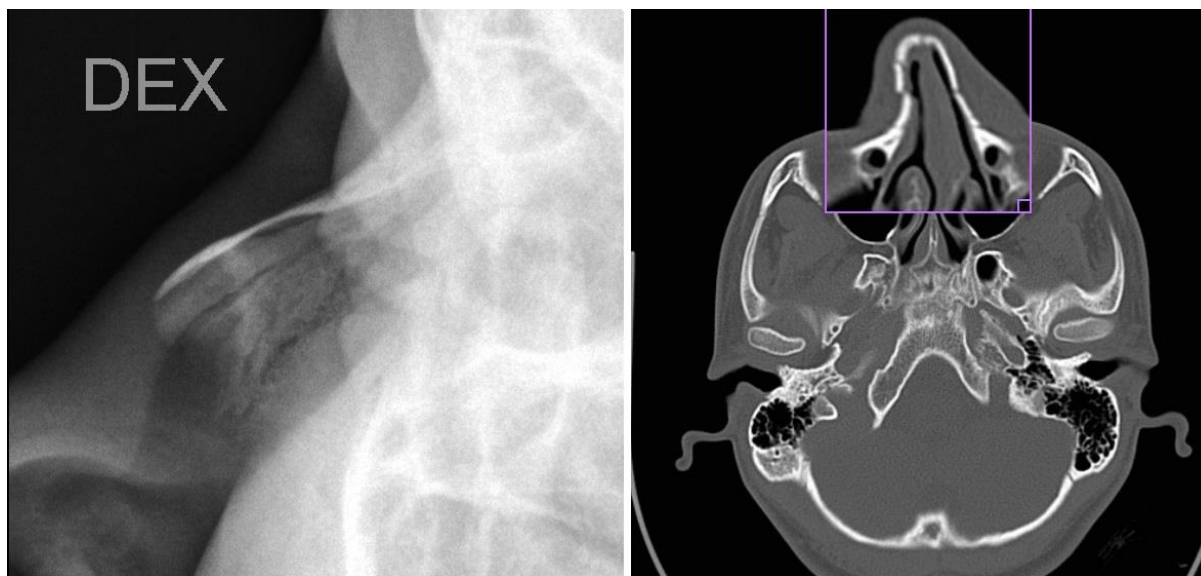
On the left: a plain film radiograph of the right nasal bone of a patient from this study. Note the seemingly normal appearance of the nasal bone. On the right: a head CT scan of the same patient, performed on the same day as the radiograph. Note the fracture of the right nasal bone with a slight dislocation (white arrow)
